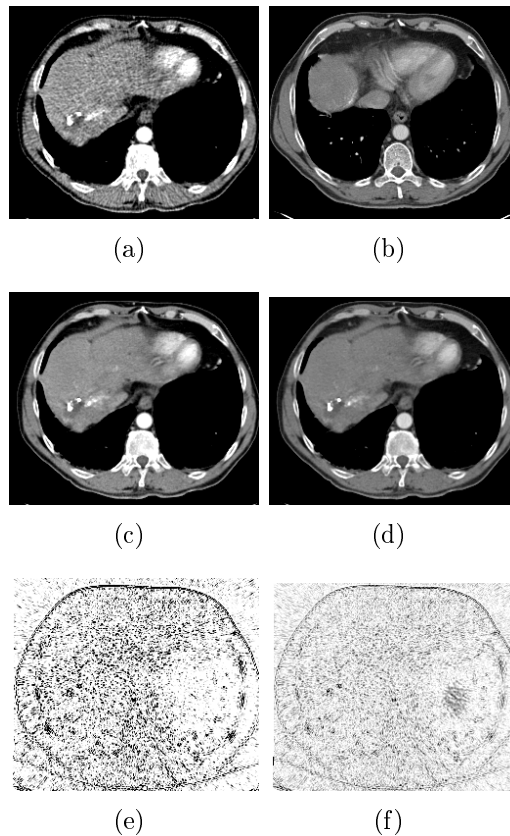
2D views of registration results for synthetic slices without deformation. (a) shows a 2D CT synthetic slice including noise. (b) shows the starting position for optimization with an RMS of  $20.12mm$  for translation and  $5.4^\circ$  for rotation. (c) shows the estimated minimum (M-estimator) with an RMS of  $0.86mm$  for translation and  $0.004^\circ$  for rotation. (d) shows the estimated minimum (AM-estimator) with an RMS of  $0.08mm$  for translation and  $0.0009^\circ$  for rotation. (e) and (f) show the weights image in the estimated minimum for the M- and AM-estimator respectively.
